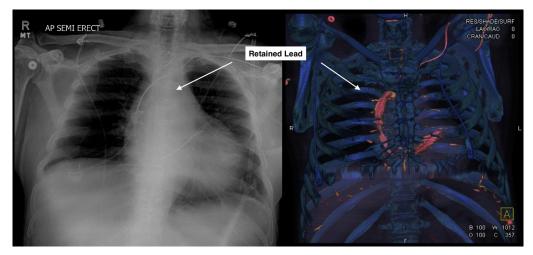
Chest radiograph and 3-dimensional computed tomography of abandoned lead.
